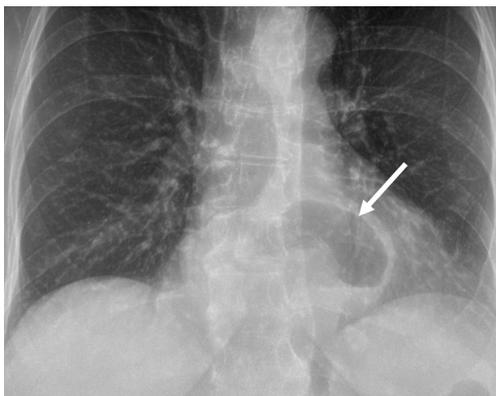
X-ray demonstrating retrocardiac lucency (arrow) from a type III paraesophageal hernia.
